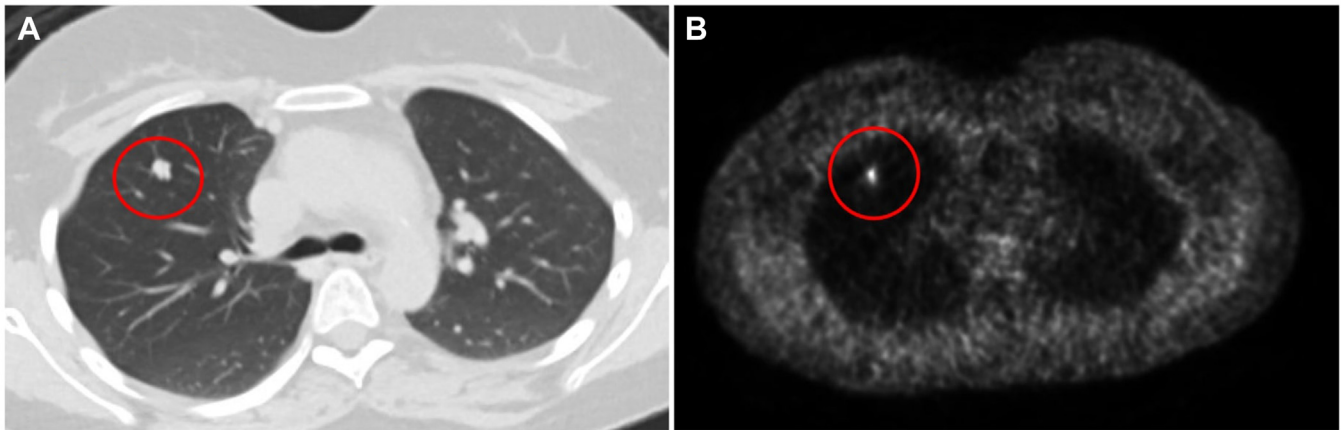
Chest computed tomography scan notable for a 1-cm right upper lobe nodule (A) subsequently analyzed by gallium-68 DOTATATE positron emission tomography computed tomography (B) identifying it as a mildly radiotracer-avid lung nodule.
